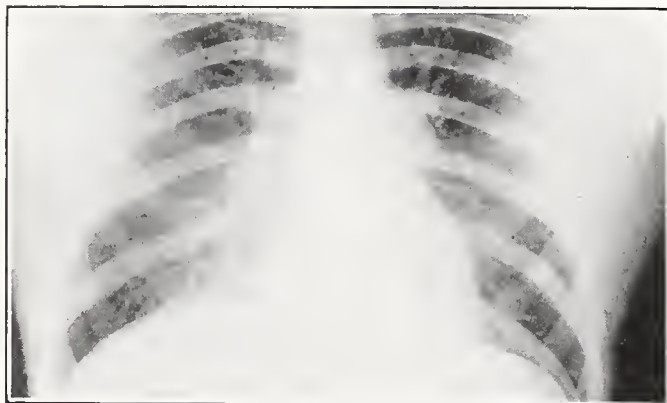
(Case 3).—Radiograph of the chest shows practically normal lung with moderate increased density of hila and peribronchial glands shadows.
